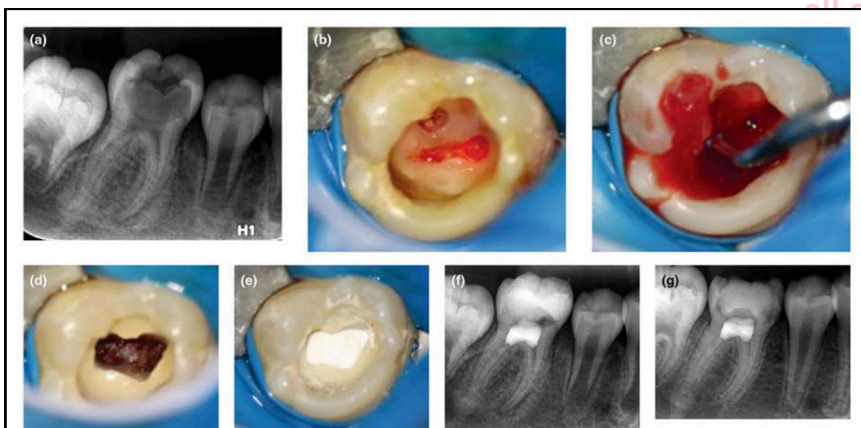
Right first mandibular molar tooth (#46) had deep and large occlusal caries into the pulp, in a 11-year-old girl. (a) A preoperative PA radiograph showing periapical lesion (PAI score=3). (b) A clinical photograph showing the initial pulp exposure after caries removal. (c) A clinical photograph of pulp bleeding. (d) A clinical photograph when haemostasis was obtained. (e) A clinical photograph showing capping of wound with iRoot BP Plus. (f) Immediate postoperative radiograph showing a full pulpotomy. (g) A PA radiograph at a 20-month follow-up. The patient was referred for a new restoration due to recurrent caries.
